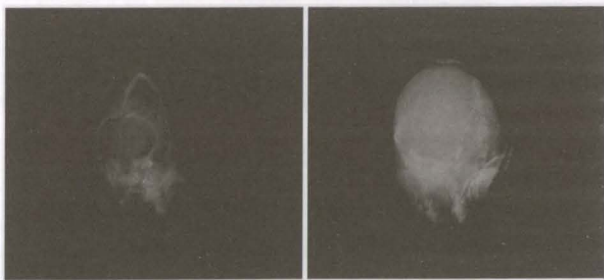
Volume Rendering of CT (left) and MRI (right)
